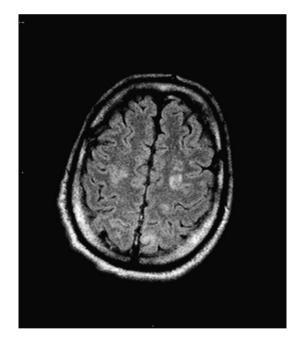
T2 diffusion-weighted MRI showing multiple hyperintensities compatible with PRES.
